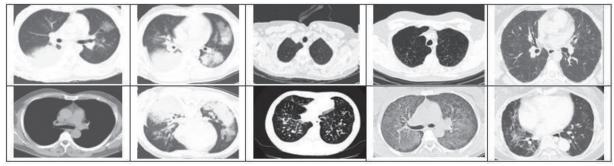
Non COVID images from CT scan Dataset
